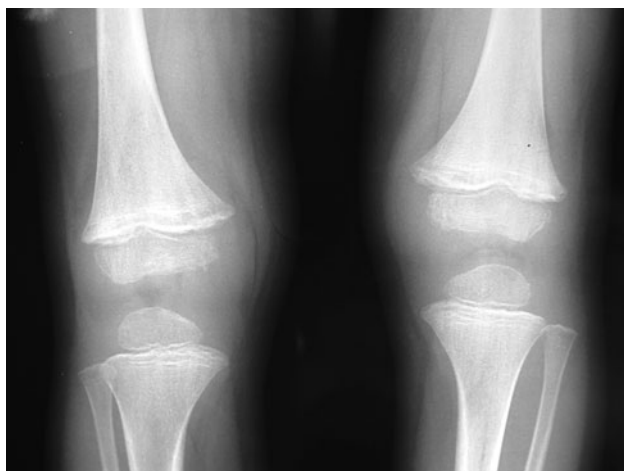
Anteroposterior radiograph of the knees, showing a dense line at the growing metaphyseal end of the femora involving the provisional zone of calcification
